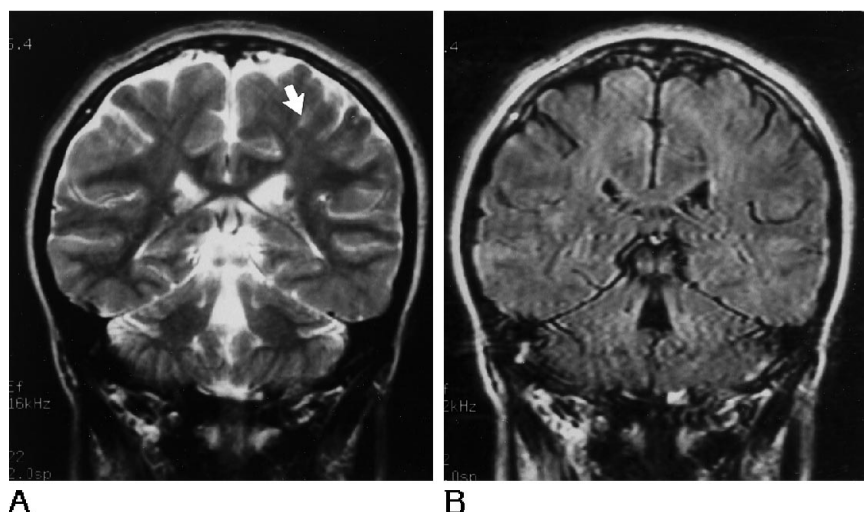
A and B, T2-weighted images (4000/100) of the brain of patient 2 showed a linear high-intensity lesion (arrow, A) in the left parietal region like a myelination line. But FLAIR images (7000/160; inversion time, 2000) demonstrated low intensity at the corresponding site, which represented the partial volume effect of CSF.
